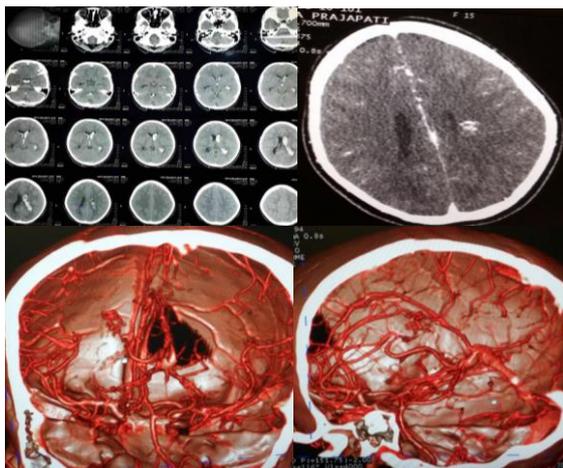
Preoperative images, A) CT scan of brain showing intraventricular hemorrhage in bilateral lateral ventricles with early hydrocephalus, B) Contrast CT scan showing ArterioVenous Malformation (AVM) in left parietal lobe, C & D) CT angiography showing AV
